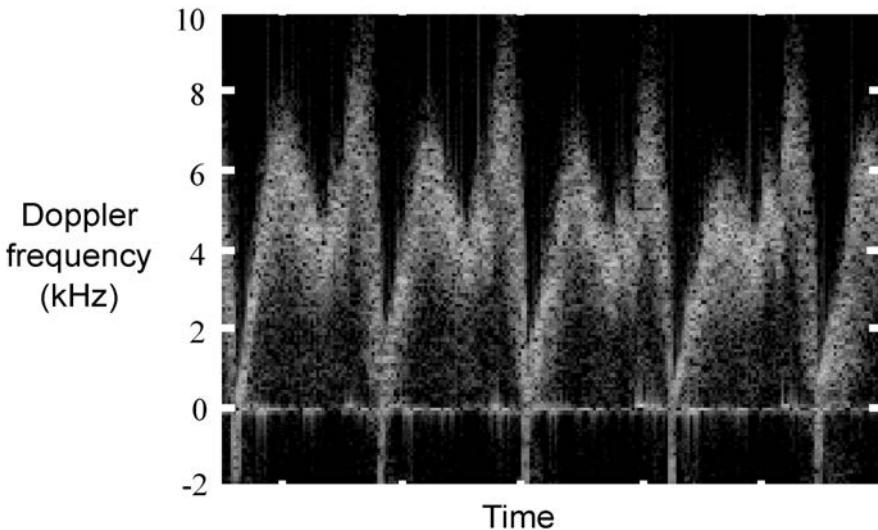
Representative pulsed Doppler spectral display.
